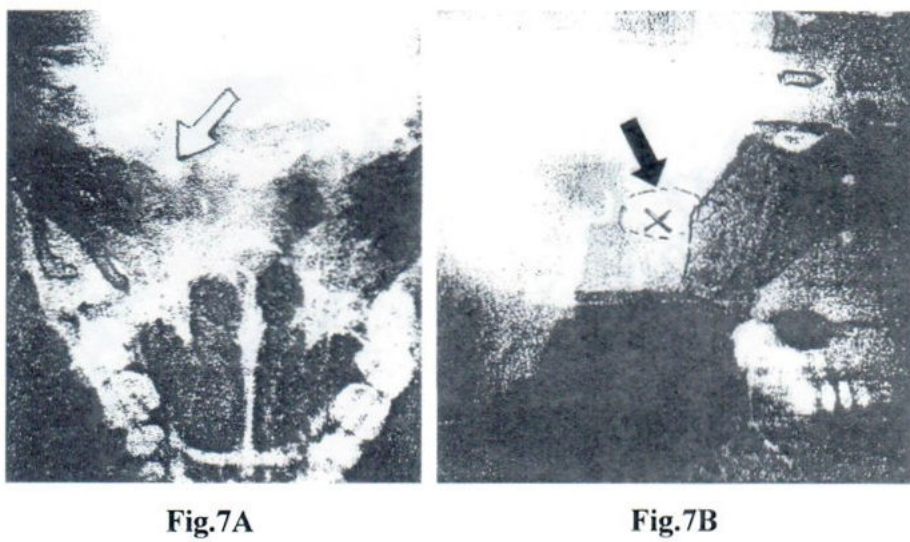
X-ray picture of the base of Skull showing the erosion as pointed by an arrow at the Petrosphenoidal Region.
